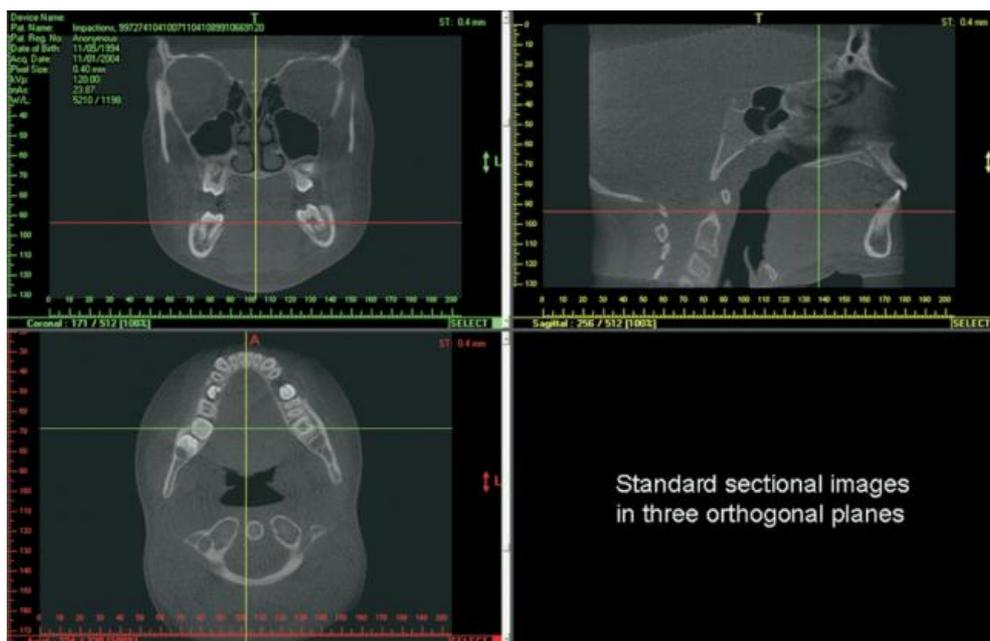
Initial presentation of CBCT image slices in three orthogonal planes
